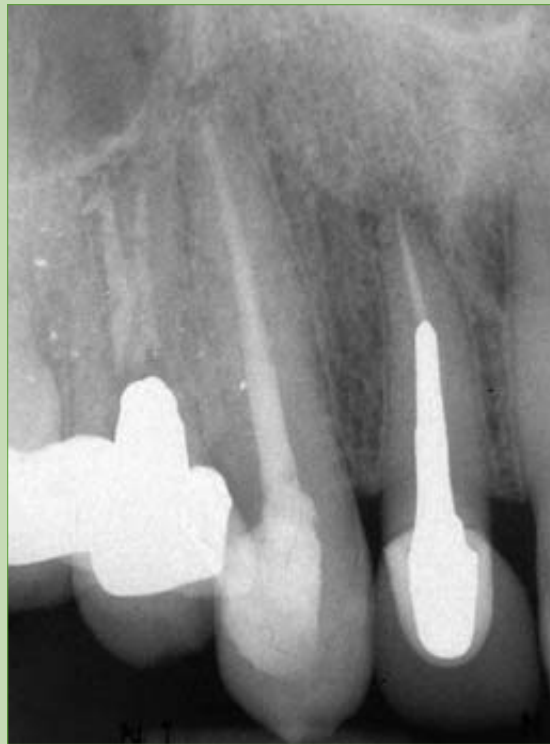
Post and core and crown showing periapical radiolucency 11 years later (2006).
